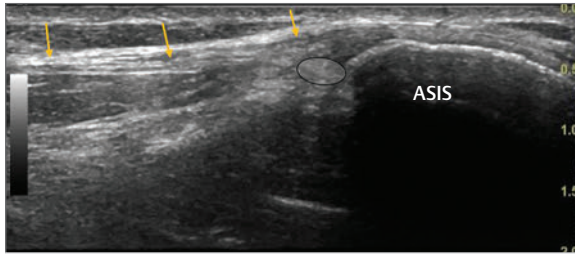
Ultrasound image of the anterior superior iliac spine (ASIS) and the medial inguinal ligament (yellow arrows). The probe has been placed in the transverse oblique plane so that its medial edge lies over the ASIS. Immediately medial to the ASIS and deep to the inguinal ligament the lateral cutaneous nerve of the thigh may be seen (black oval).
